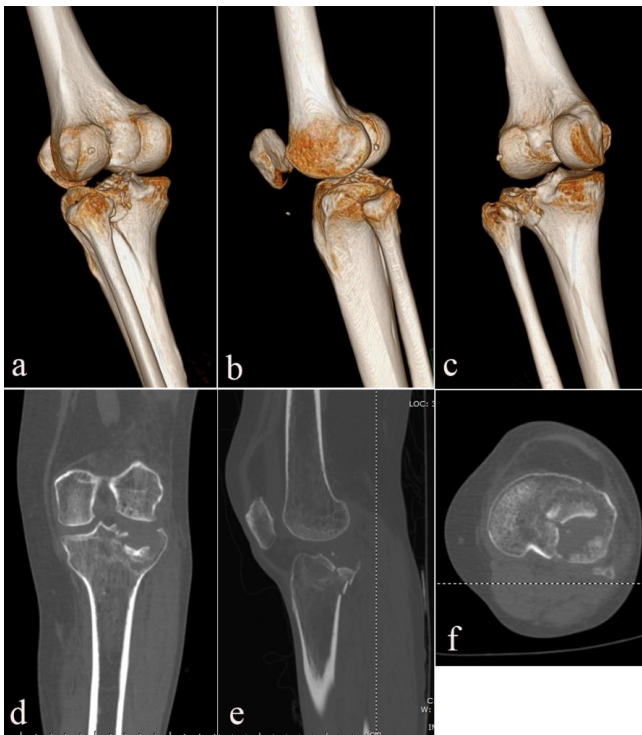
Preoperative CT and three-dimensional reconstruction views clearly showed the split and expression of the lateral tibial plateau involving the posterolateral aspect. a-c Three-dimensional reconstruction view. d Coronal view. e Sagittal view. f Axial view.
